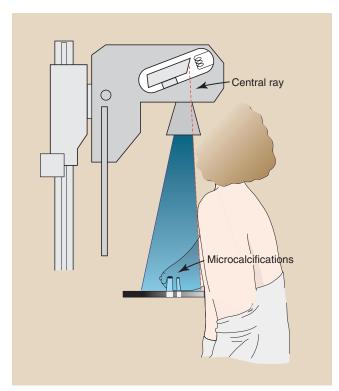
When the x-ray tube is tilted in its housing, the effective focal spot is small, the x-ray intensity is more uniform, and tissue against the chest wall is imaged.
